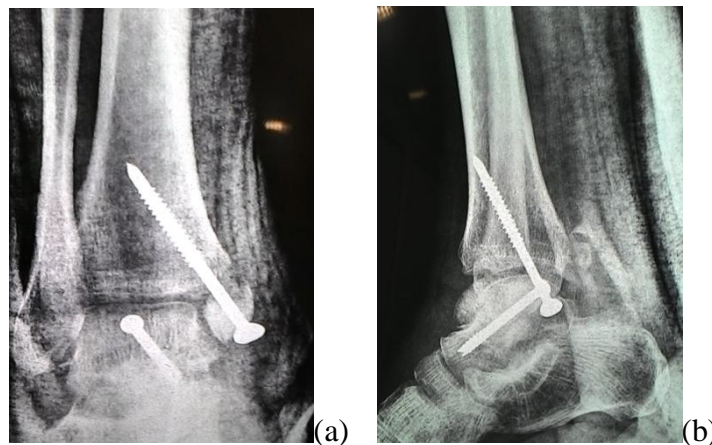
immediate post operative radiographs
